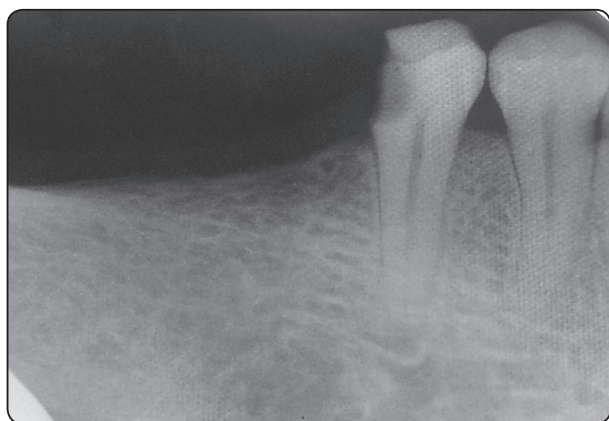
A radiograph of a tooth suffering irreversible pulpitis.
